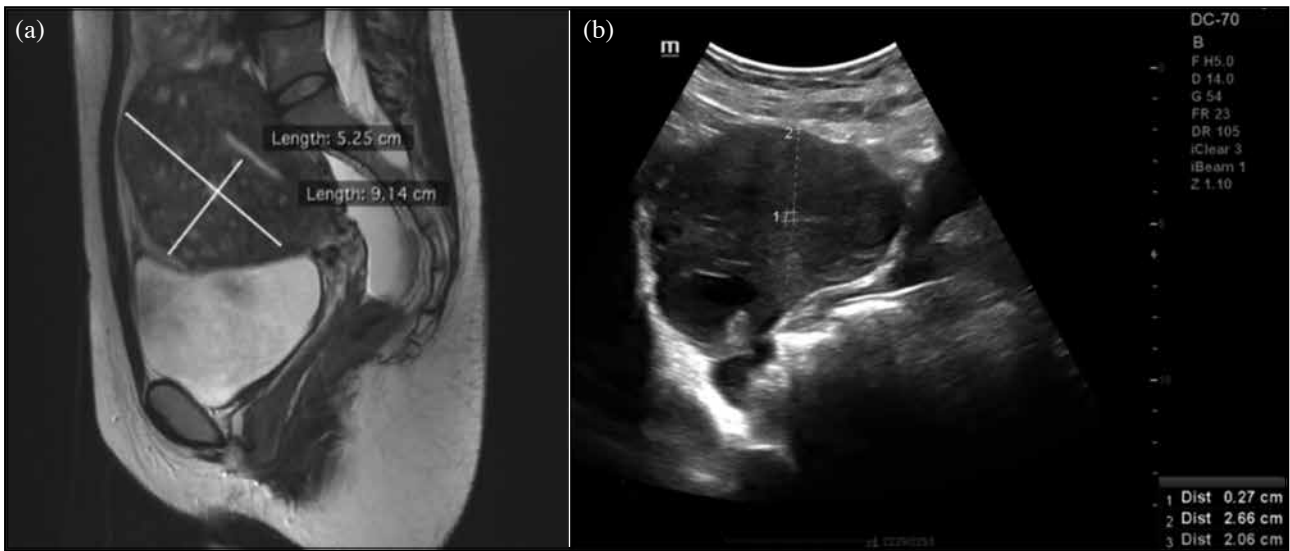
(a) Magnetic resonance imaging showing an extensive adenomyosis at the anterior wall of the uterus, with the wall thickness being 5.25 cm. (b) Ultrasonography at 8 weeks after delivery showing the uterus without features of adenomyosis, with the anterior wall thickness reduced to 2.66 cm.
